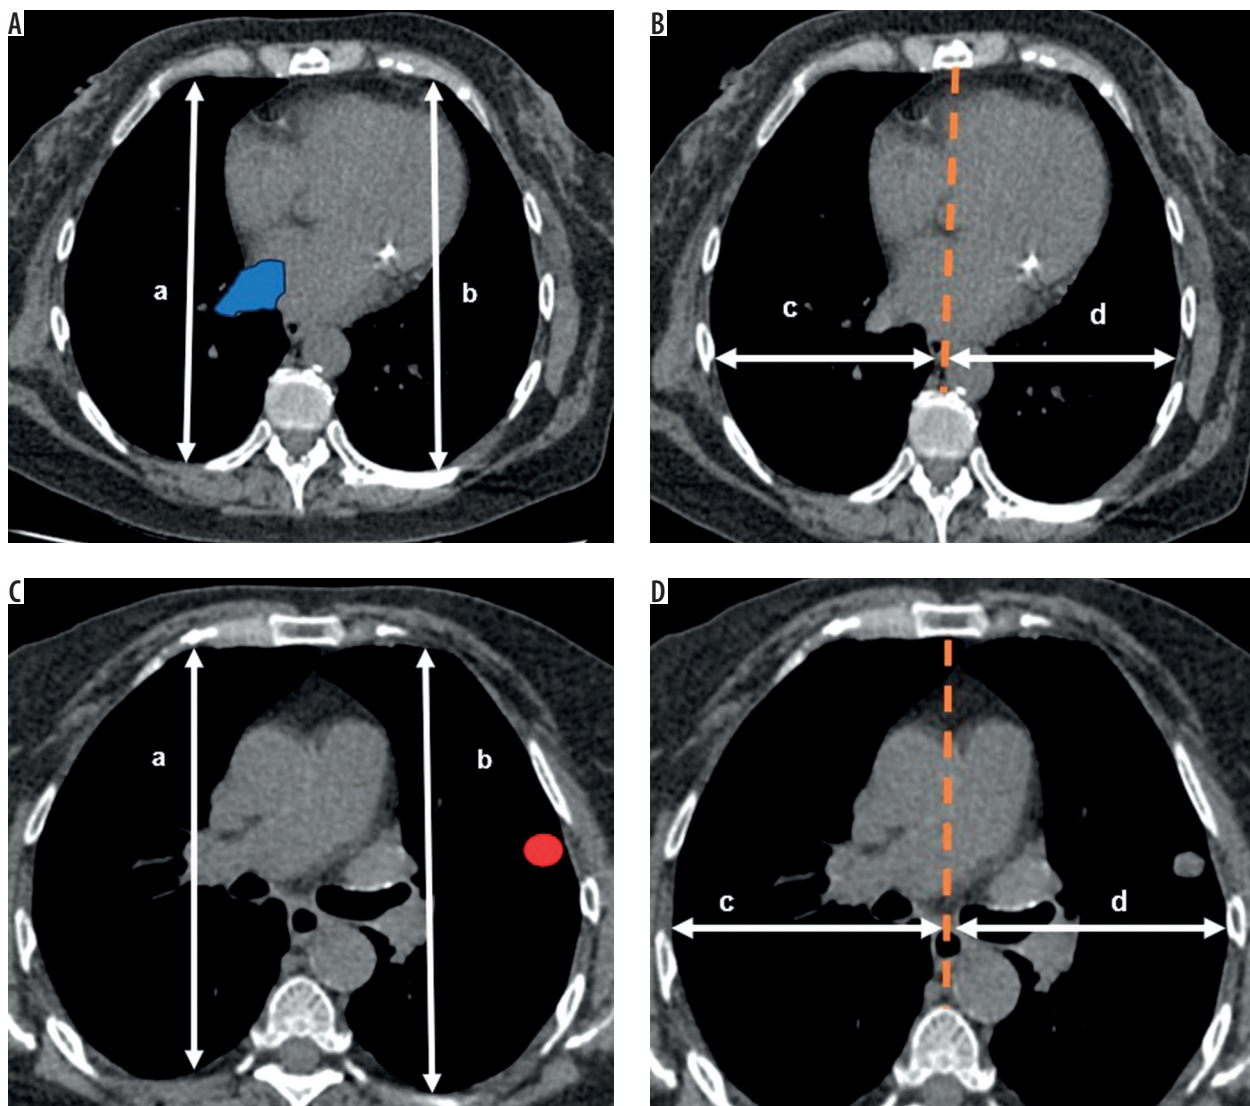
Chest wall deformity measurements. Calculations include anteroposterior (AP) and transverse (T) asymmetry, as well as hemithorax flatness (F – only at the target lesion site). A dashed line extending from the midline of the vertebral body to the midline of the posterior surface of the sternum divides the thorax into two halves. (A, B) Measurements taken at the level of the right inferior pulmonary vein (anatomical landmark; blue in A) on pre-biopsy thoracic computed tomography (CT). (C, D) Measurements at the level of the target lesion (red in C) on the interventional CT images
